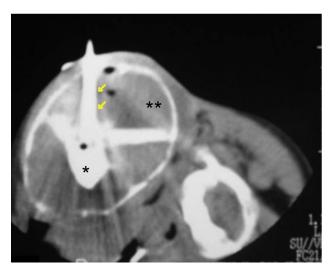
Axial CT image showing an 11-gauge needle (arrows) inserted into the ABC (double asterisk) and mixture of bone particles, autologous bone marrow, and nonionic contrast medium injected into the cyst (single asterisk).
